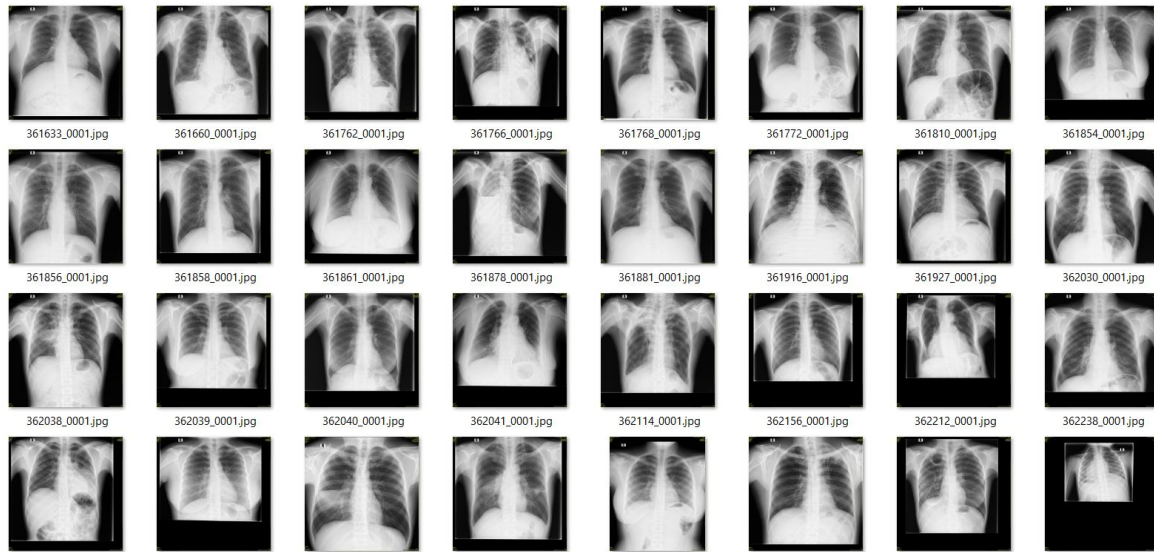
Sample Local Chest X-ray Images before Preprocessing
